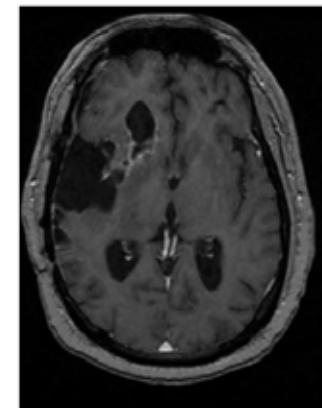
Axial T1-weighted MR image with gadolinium contrast 4 1/2 months after re-treatment showing stable imaging findings.
